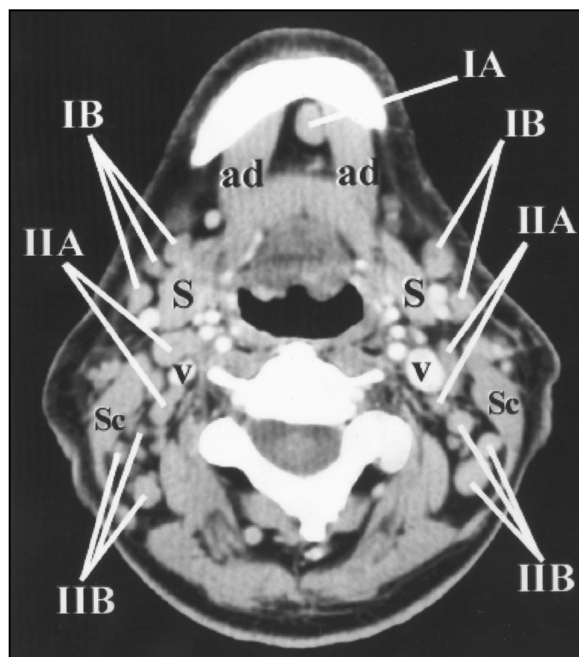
36-year-old HIV-positive man. Axial contrast-enhanced CT scan of neck through level of lower mandible and above hyoid bone shows level IA node between medial margins of anterior bellies of digastric muscles (ad). Level IB nodes are lateral to level IA nodes and anterior to back of submandibular glands (S). Levels IIA and IIB nodes are seen bilaterally. v = internal jugular veins, Sc = sternocleidomastoid muscles.
